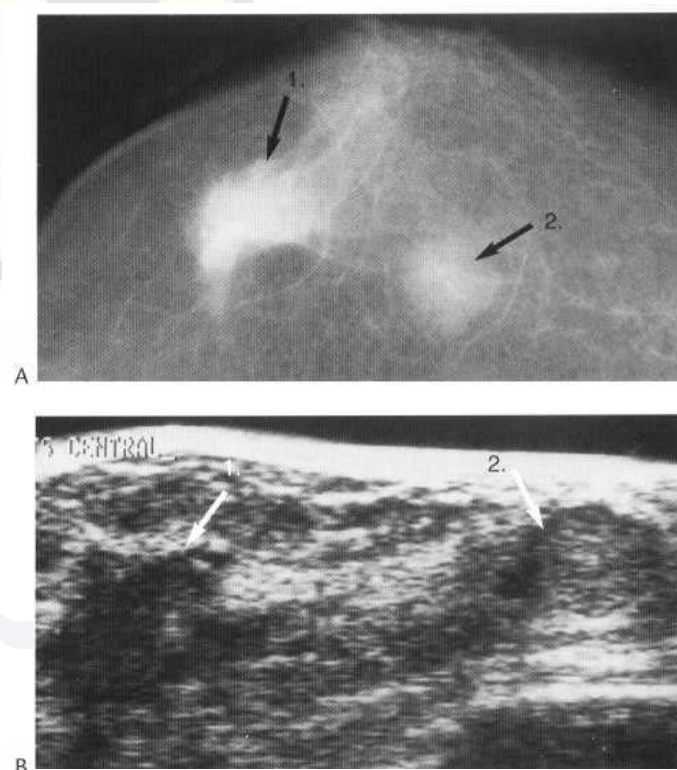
Mutinous carcinoma and invasive ductal carcinoma. (A) Mammogram shows a poorly defined spiculate mass: (1) due to invasive ductal carcinoma and a circumscribed soft-tissue mass; (2) due to a mucinous carcinoma. (B) Ultrasound shows a typical low reflectivity mass: (1) due to invasive ductal carcinoma, and a circumscribed mass with posterior acoustic accentuation due to the mutinous carcinoma (2).
